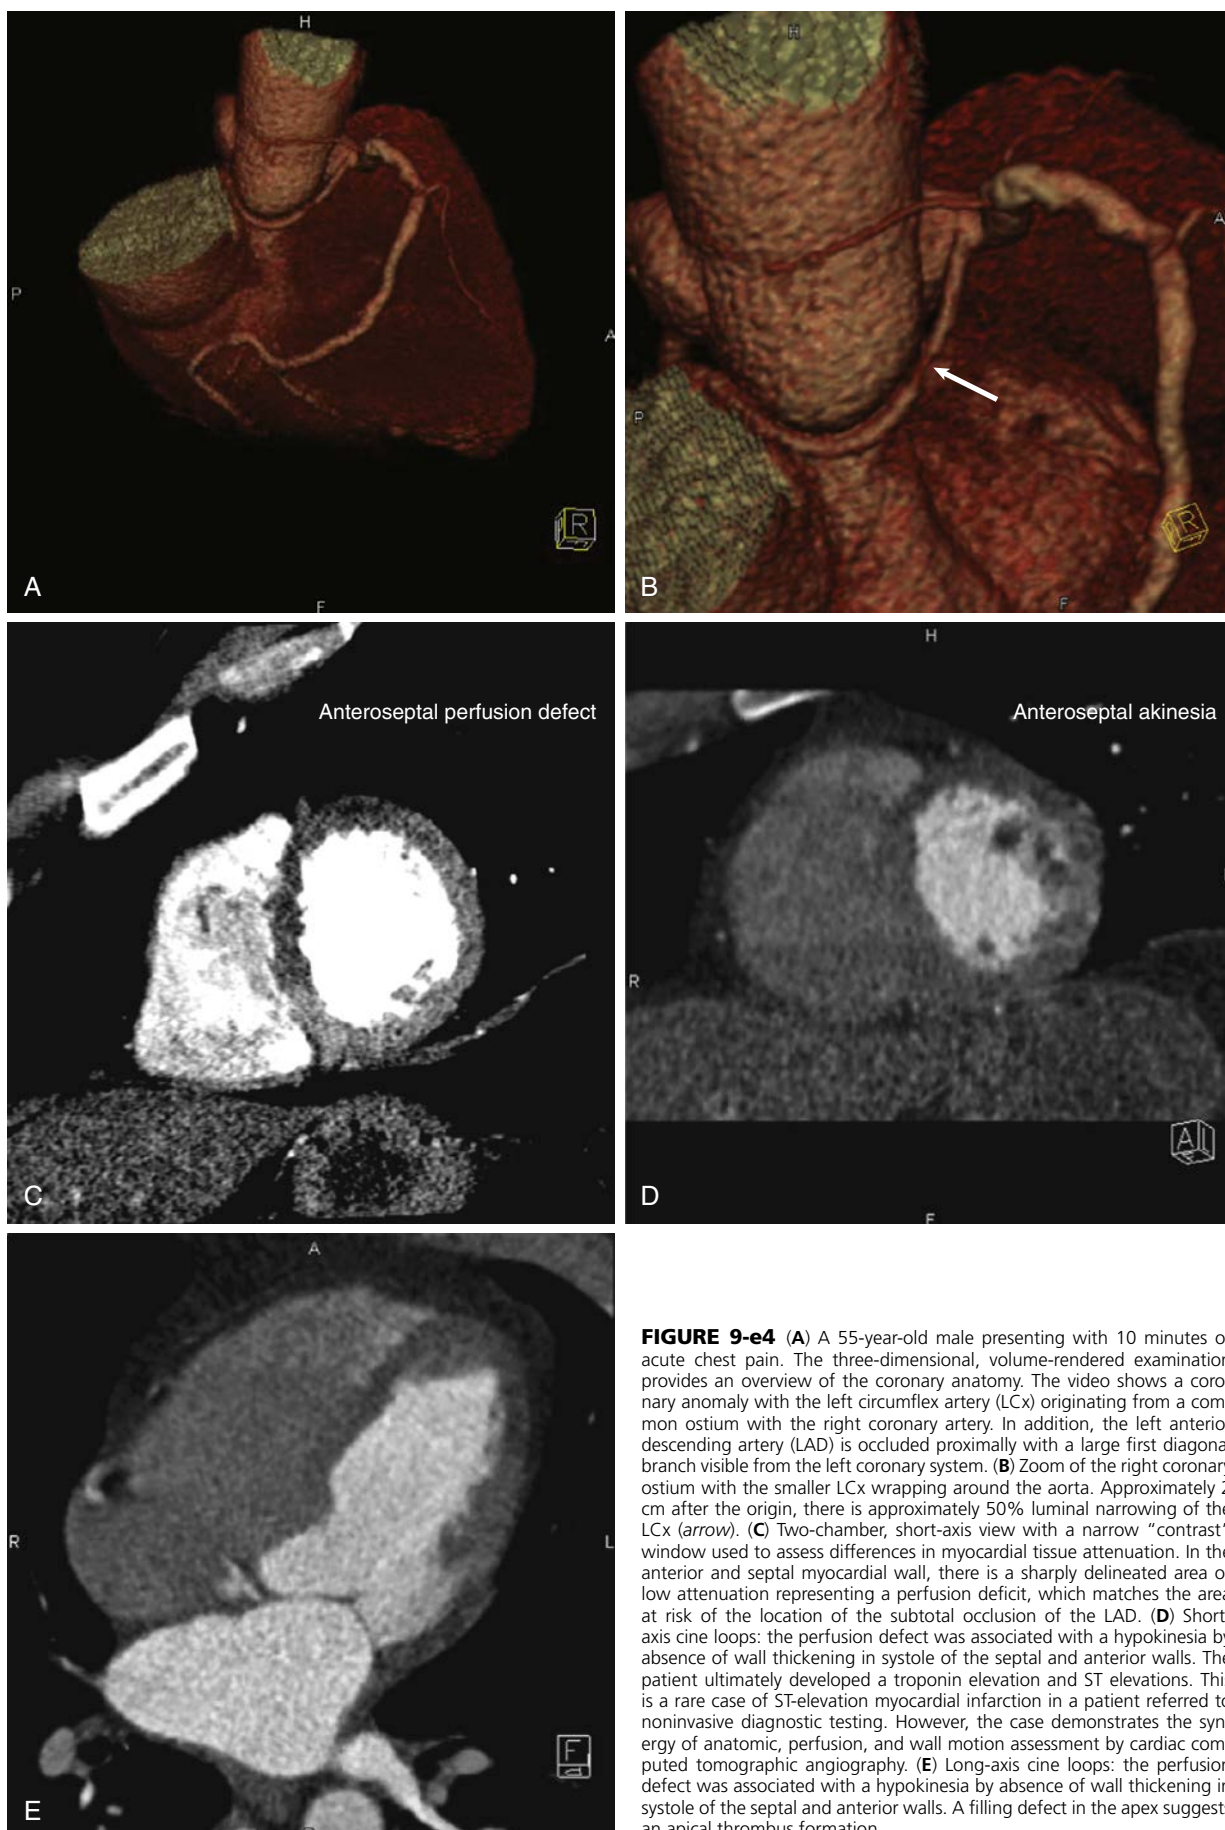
e4 (A) A 55-year-old male presenting with 10 minutes of acute chest pain. The three-dimensional, volume-rendered examination provides an overview of the coronary anatomy. The video shows a coronary anomaly with the left circumflex artery (LCx) originating from a common ostium with the right coronary artery. In addition, the left anterior descending artery (LAD) is occluded proximally with a large first diagonal branch visible from the left coronary system. (B) Zoom of the right coronary ostium with the smaller LCx wrapping around the aorta. Approximately 2 cm after the origin, there is approximately 50% luminal narrowing of the LCx (arrow). (C) Two-chamber, short-axis view with a narrow “contrast” window used to assess differences in myocardial tissue attenuation. In the anterior and septal myocardial wall, there is a sharply delineated area of low attenuation representing a perfusion deficit, which matches the area at risk of the location of the subtotal occlusion of the LAD. (D) Short-axis cine loops: the perfusion defect was associated with a hypokinesia by absence of wall thickening in systole of the septal and anterior walls. The patient ultimately developed a troponin elevation and ST elevations. This is a rare case of ST-elevation myocardial infarction in a patient referred to noninvasive diagnostic testing. However, the case demonstrates the synergy of anatomic, perfusion, and wall motion assessment by cardiac computed tomographic angiography. (E) Long-axis cine loops: the perfusion defect was associated with a hypokinesia by absence of wall thickening in systole of the septal and anterior walls. A filling defect in the apex suggests an apical thrombus formation.
